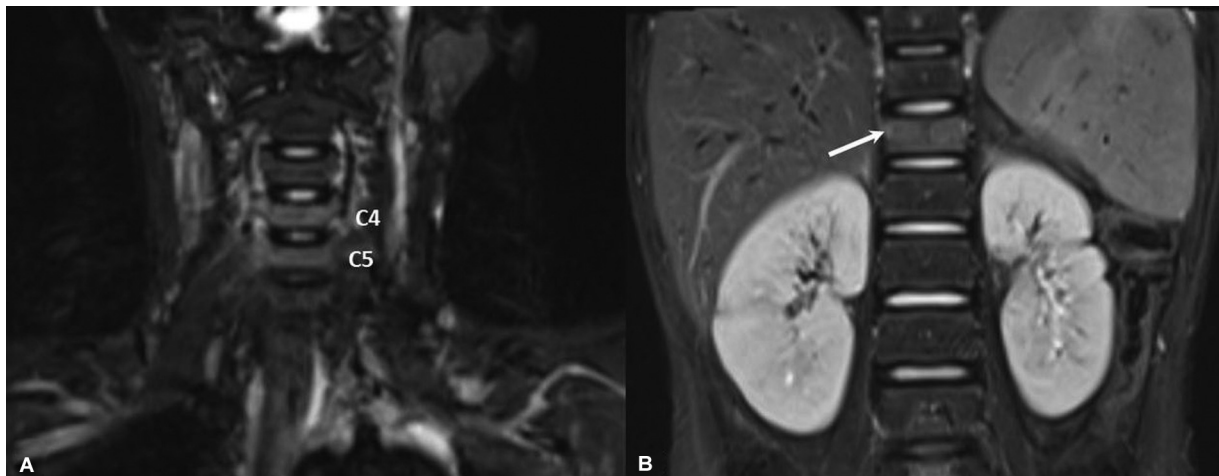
Vertebral involvement in chronic nonbacterial osteomyelitis (CNO). (A and B) Coronal short tau inversion recovery (STIR) whole body magnetic resonance imaging (WBMRI) images in a patient with CNO show hyperintense signal in C4, C5, and D12 vertebral bodies with mild reduction in height in D12 vertebra (arrow, B). Intervening disc signal and height are preserved with lack of an associated soft tissue mass.
